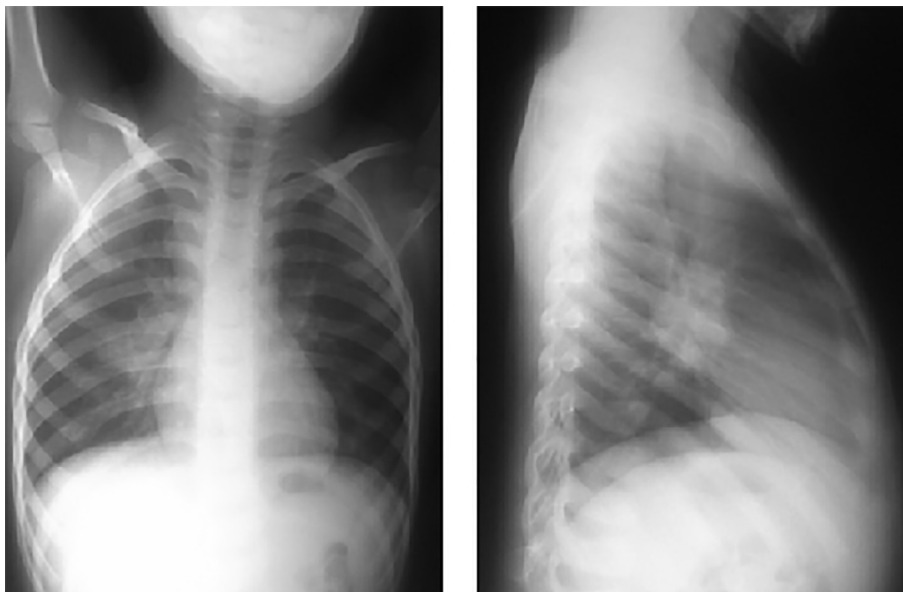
Chest X-ray, anterior and lateral views, a case of primary CTB.
